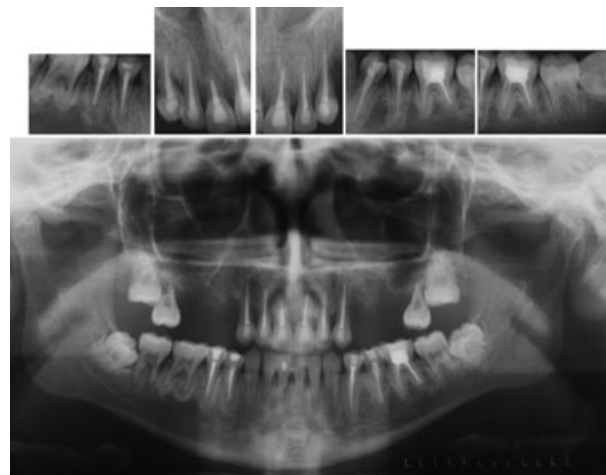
Panoramic and periapical radiographs after completion of endodontic treatment of teeth numbers 11–13, 21–23, 34–36, 44 and 45 showing apical healing. Teeth numbers 14–16, 24 and 26 were extracted.
